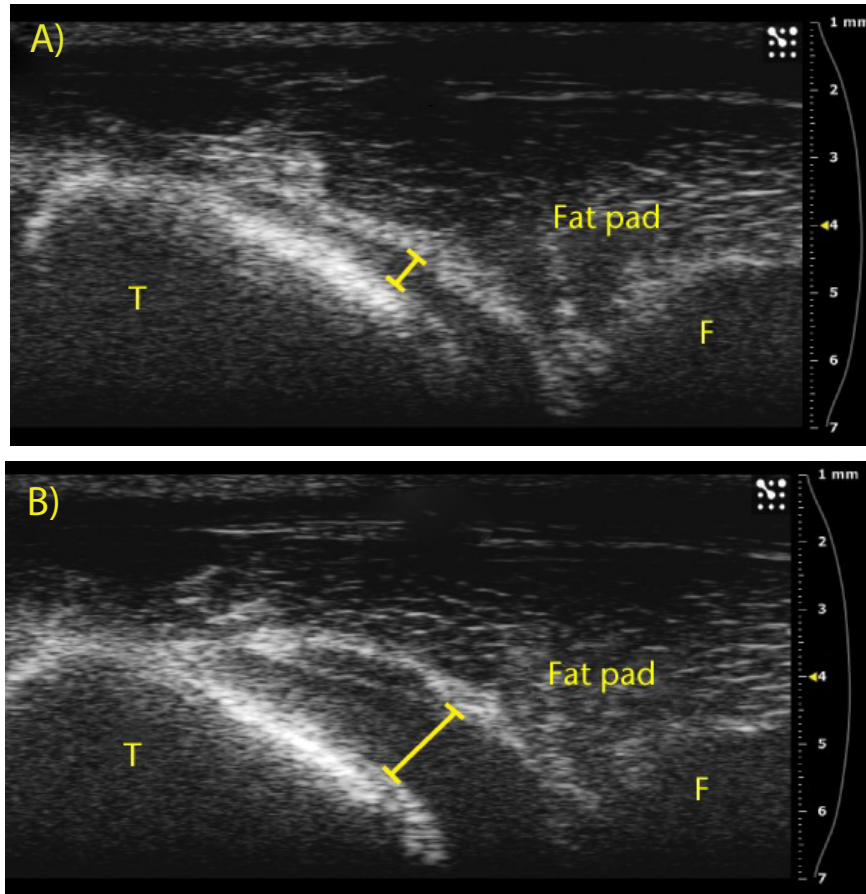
Ultrasound images showing substantial separation of the fat pad from the tibia (A) before and (B) after an injection.
